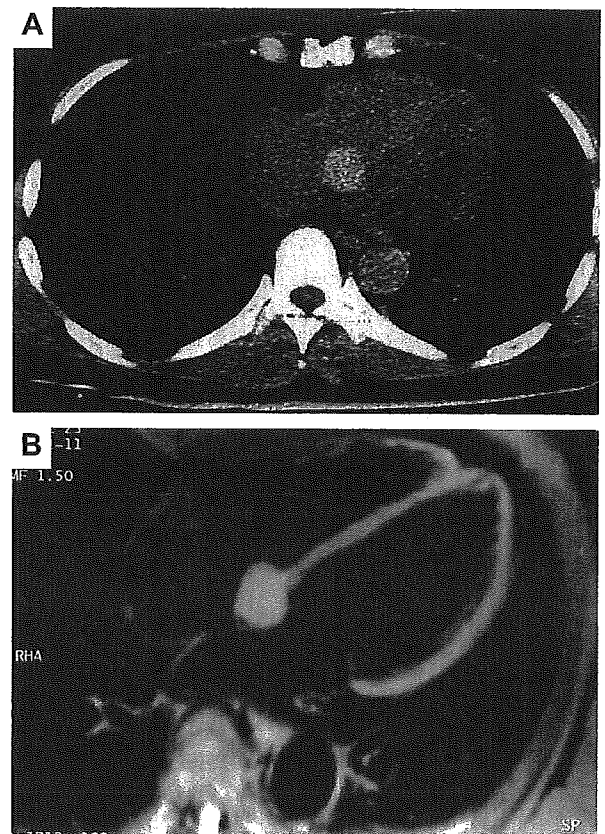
(A) Computed tomography scan and (B) magnetic resonance imaging showing intracardiac tumor with a broad connection to the interatrial septum.
